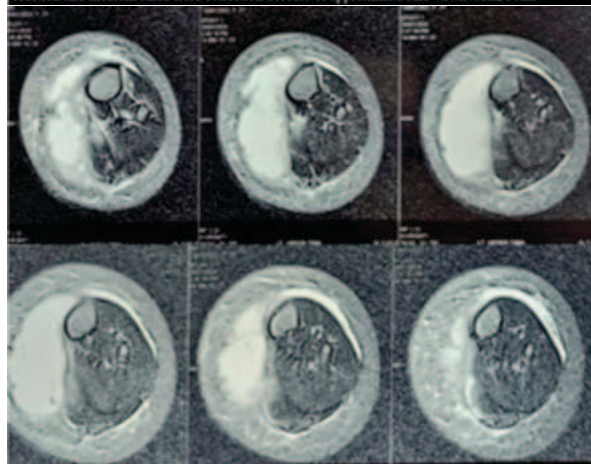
MRI Axial plane of Left Knee showing soft tissue thickening, periosteal reaction and medium sized fluid collection/abscess of approximate size 4x4x3.8cm (30ml)
